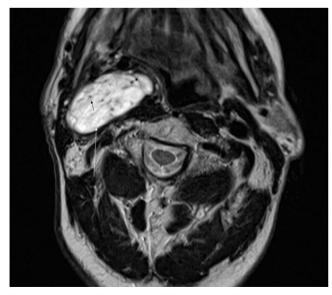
Axial T2-weighted MRI showing a high signal right carotid space mass (white arrow) containing several signal voids (small black arrows) consistent with a paraganglioma.
